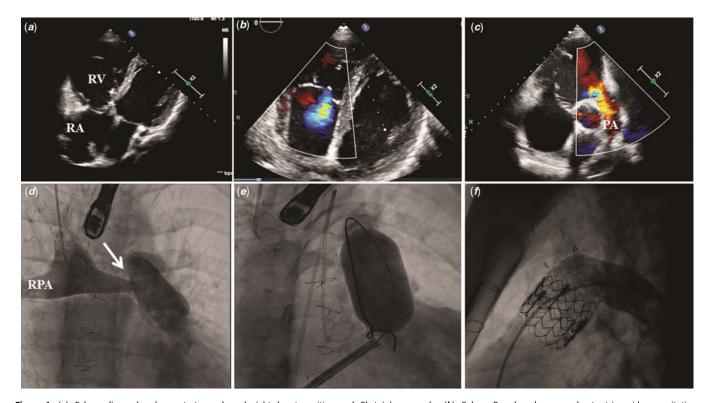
(a) Echocardiography demonstrates enlarged right heart cavities and Ebstein's anomaly. (b) Colour Doppler shows moderate tricuspid regurgitation. (c) Echocardiography demonstrates severe pulmonary insufficiency. (d) Pulmonary artery angiogram through the Glenn anastomosis in the anteroposterior projection shows severe pulmonary insufficiency and proximal right pulmonary artery stenosis (arrow). (e) Contrast injection after the balloon was inflated to nominal pressure. (f) Pulmonary artery angiogram in the lateral projection after valve deployment shows valve position and no residual pulmonary regurgitation; RA: right atrium, RV: right ventricle, MPA: main pulmonary artery.
